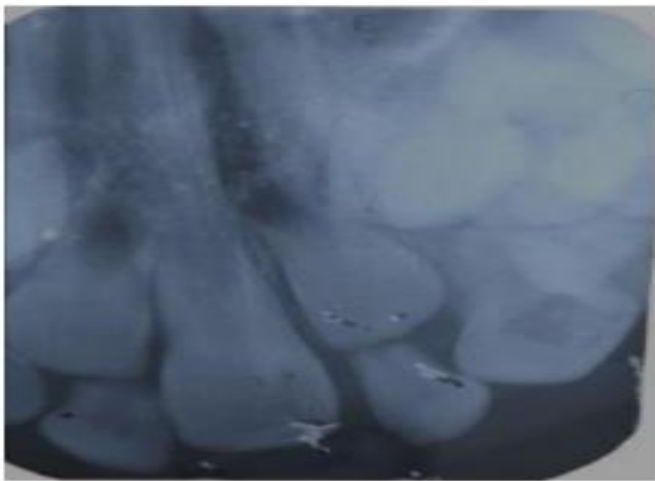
Intraoral periapical radiograph showing incomplete root formation
